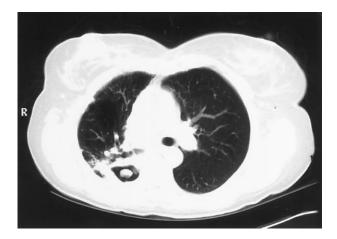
Chest CT scan of a patient with a history of lung cancer and tuberculosis, who developed aspergilloma after undergoing resection of the right upper lobe.
